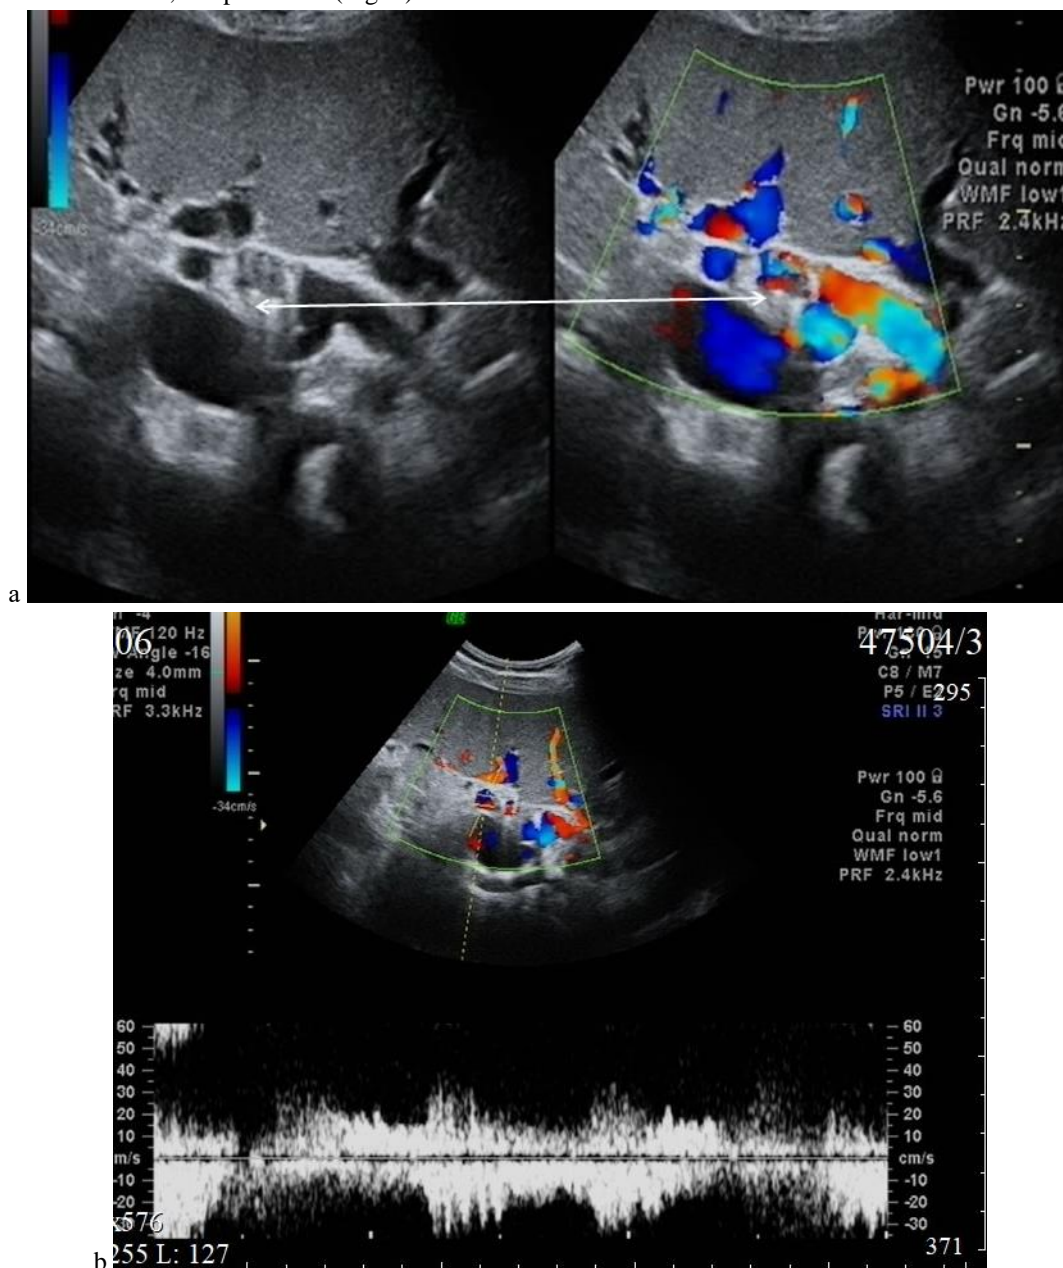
Ultrasound images
